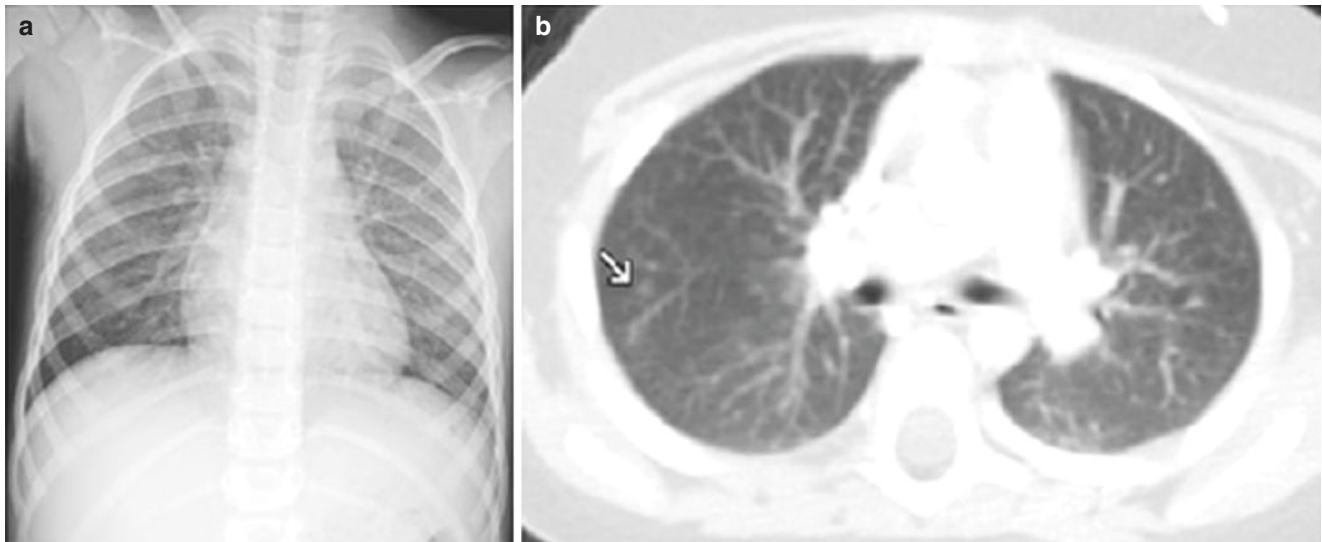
(a) Acute Langerhans cell histiocytosis (LCH): CXR shows mild nonspecific ILD suggesting bronchial wall thickening, which is often the first imaging evidence of LCH. (b) Acute LCH: axial lung window CT image reveals multiple small nodules (*arrow*), dominantly in the upper lobes
